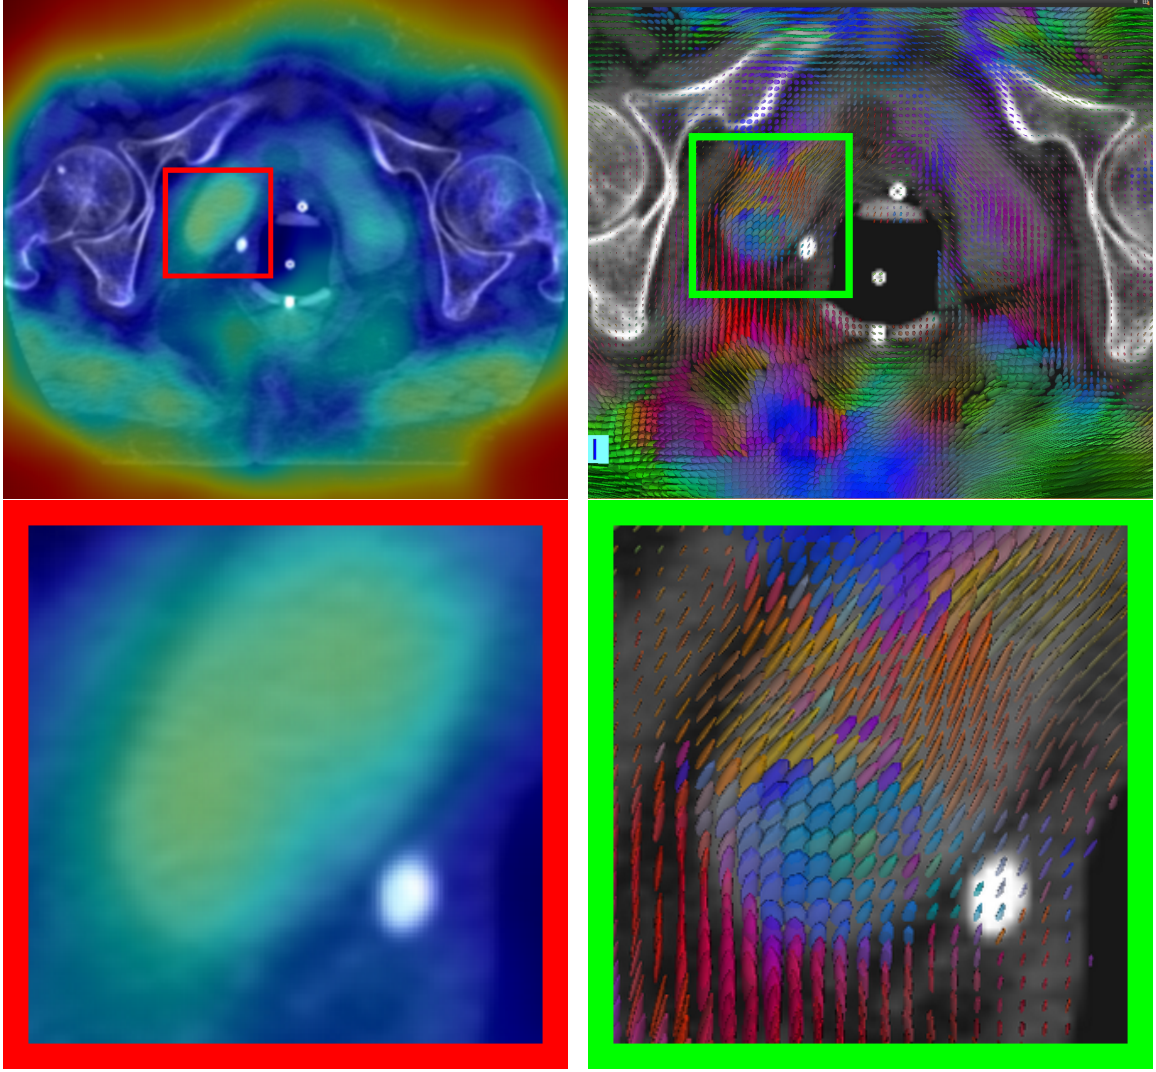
Scalar (left) and tensor (right) representations of registration uncertainty overlaid on CT. In the scalar visualization, the colors of the overlay represent uncertainty ranging from most certain (blue) to most uncertain (red). This uncertainty corresponds to the volume of the ellipsoids depicted in the tensor visualization. In the tensor representation, the colors indicate the orientation of the major axis of the ellipsoid or direction of maximum uncertainty. Note that this exemplar registration result is more certain at rigid structures (bones) compared to deformable ones (bladder, bowels, and air) and the tensor orientations follow the edge information in the image.
